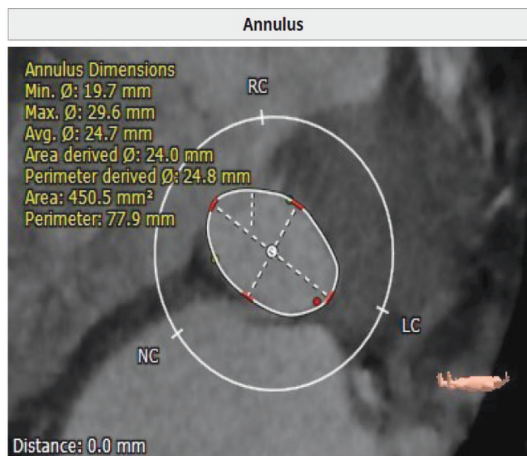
CT aortic valve, patient No 2
